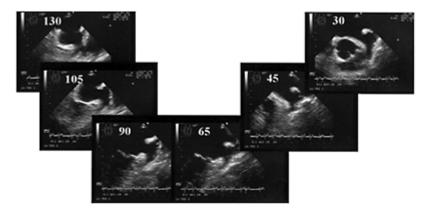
Left atrial appendage shown from multiple views by multiplane transesophageal echocardiography. Numbers in the upper left corner indicate rotation degrees of multiplane probe.
